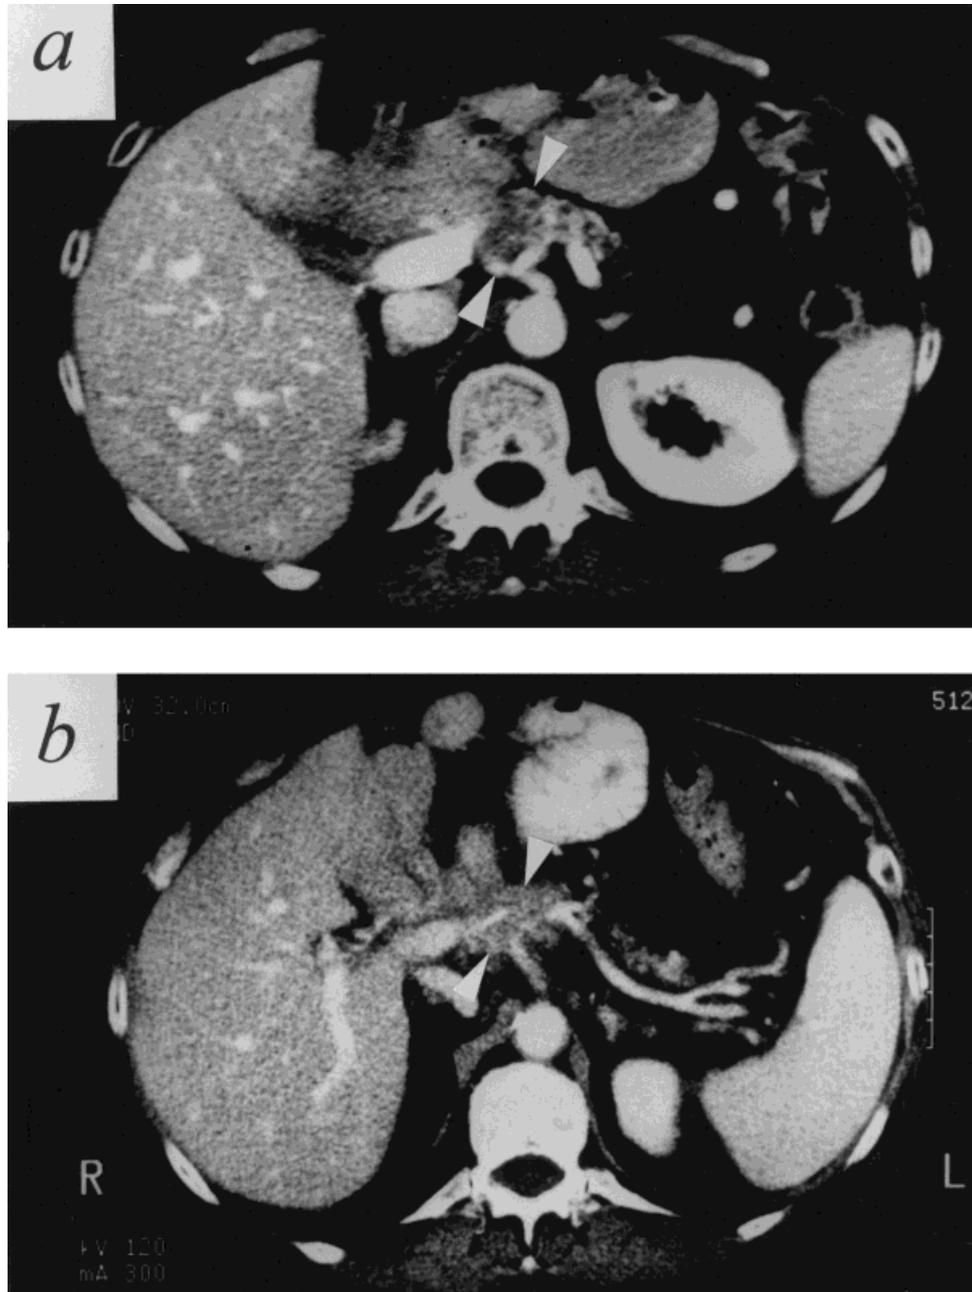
Regression of a non-resectable pancreatic tumor in a 63-year-old female patient (patient 13 in Table II). CT scan of the pancreas before (a) and after (b) 3 cycles of vaccination with mutant ras peptides. Tumor area (white arrowheads) is less prominent after vaccination with mutant ras peptides. After 28 months of follow-up, the patient was still in a good clinical state, showing stable disease.
